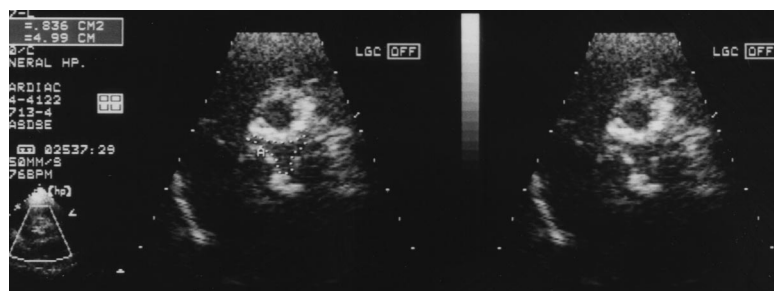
Measurement of AVA by transthoracic echocardiography in a patient with moderate aortic stenosis. The parasternal short-axis image of the aortic valve orifice was visualized during peak systole (right). Orifice area determined by planimetry was 0.84 cm² (left).
